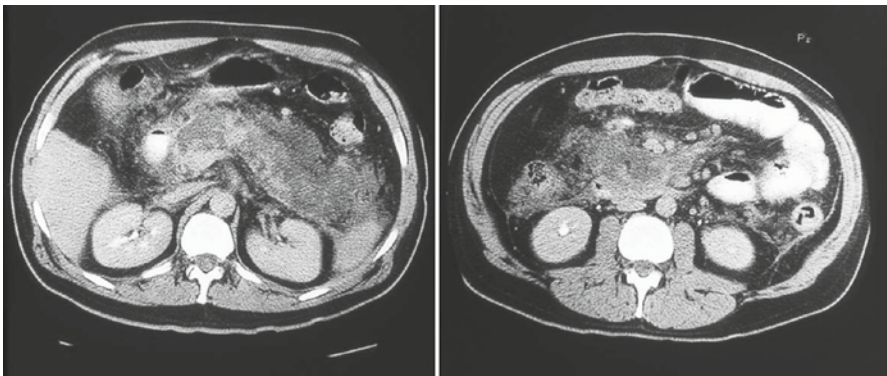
Computed tomography of the abdomen revealing changes of nonenhancement consistent with necrosis and marked interstitial edema of the pancreas
